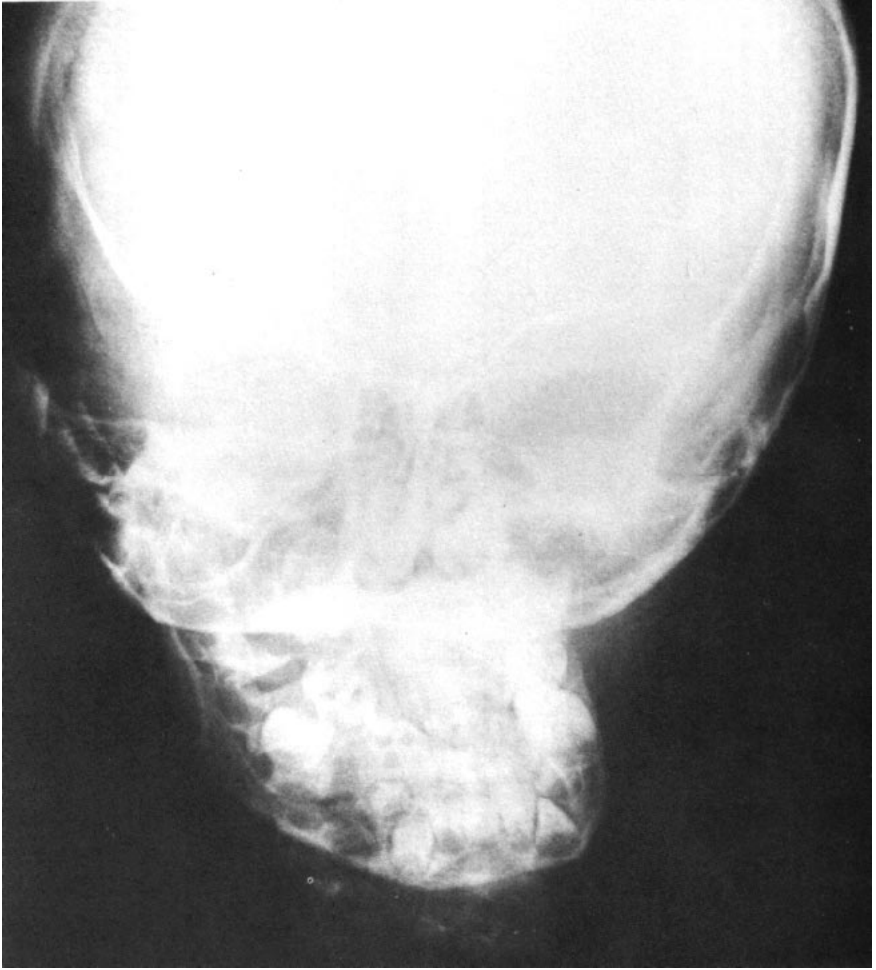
Preoperative postero-anterior radiograph
